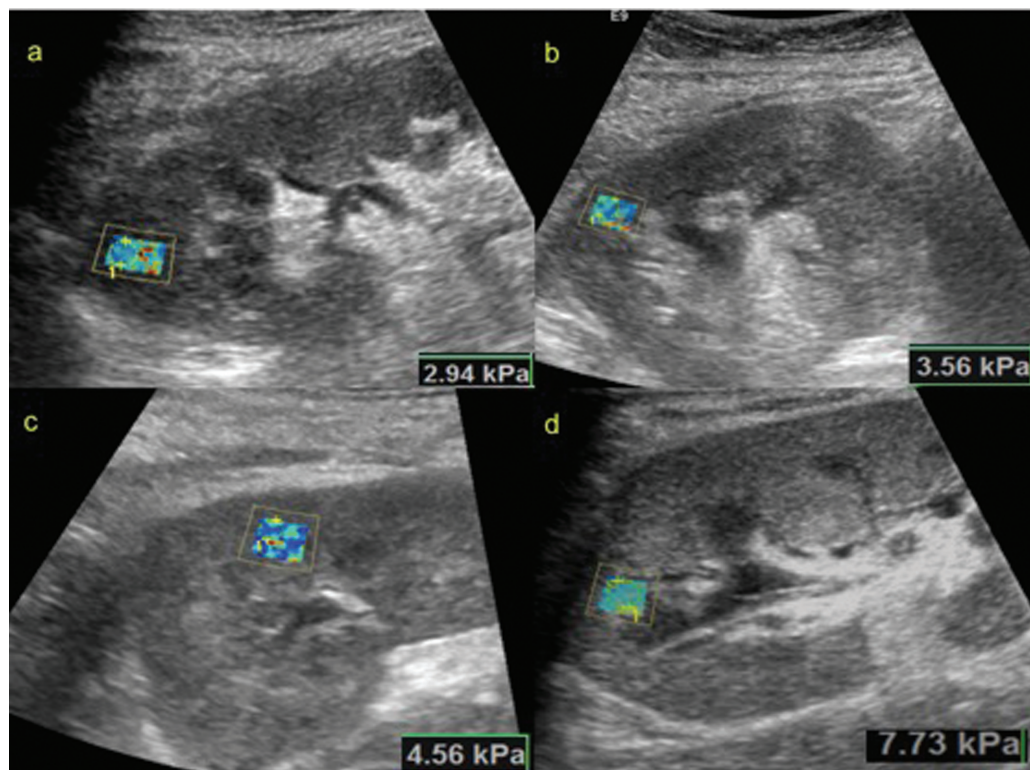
Ultrasound shear wave elastography images of transplant kidneys showing varying grades of fibrosis: (a) no fibrosis (grade 0), (b) mild fibrosis (grade 1), (c) moderate fibrosis (grade 2), and (d) severe fibrosis (grade 3).
